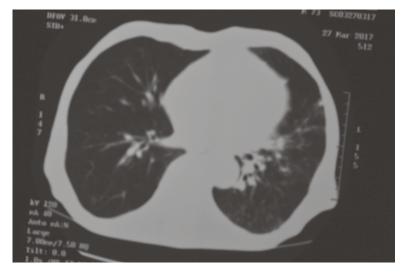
High resolution chest CT scan showing streaky densities in both lung bases worse on the left
